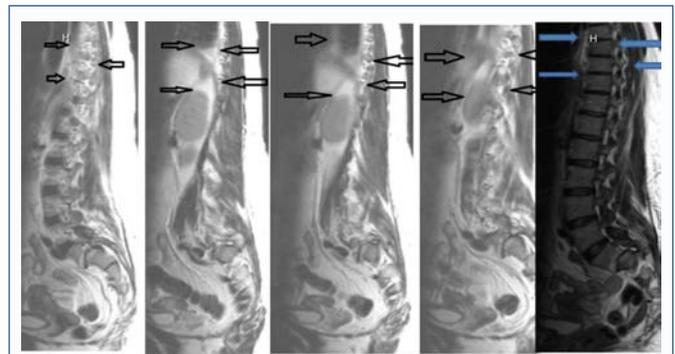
Early MRI and Missed Paraspinal Abnormality. Early MRI and chest X-ray findings at the patient's second ED presentation. Orthopaedic review identified a fusiform paraspinal mediastinal shadow on the earlier chest X-ray, consistent with a possible paraspinal collection. Review of the initial MRI - previously reported as normal - showed that the abnormality was in fact present in retrospect but had been overlooked. The registrar explained that this finding should have prompted earlier specialist referral. (Figure 1 and Figure 2, except final panel).
